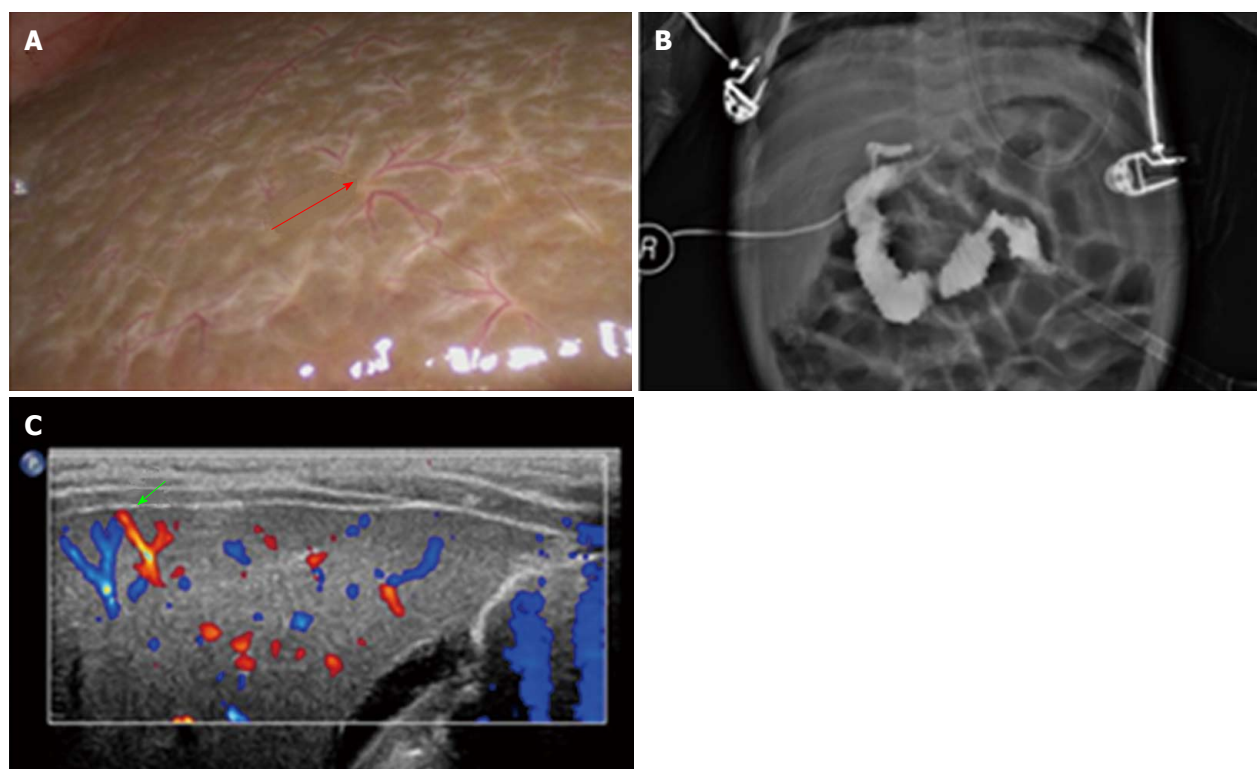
Images in a 53-day-old patient with biliary atresia. A: Dispersed type of the HSST sign (red arrow); B: Image of laparoscopic cholangiography indicates biliary atresia; C: Hepatic arterial flow extending to the hepatic surface on color Doppler US image (green arrow) indicates positive HSF. Laparoscopic HSST sign and the result of laparoscopic cholangiography were easier to identify than distinguishing HSF in a color Doppler US image. HSST: Hepatic subcapsular spider-like telangiectasis; US: Ultrasonography; HSF: Hepatic subcapsular flow.
